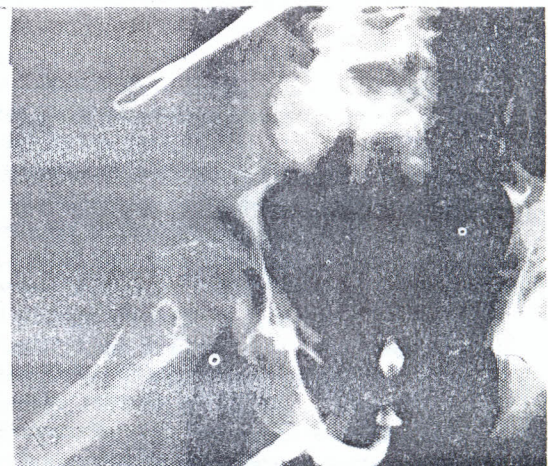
Radiograph of a post-operative peri-catheter retrograde urethrogram done six weeks after early rigid retrograde urethral realignment in the patient shown in Figure 1. This shows no extravasation of contrast which flows up to the bladder neck thus confirming restoration of urethral continuity and healing of the disrupted urethra.
